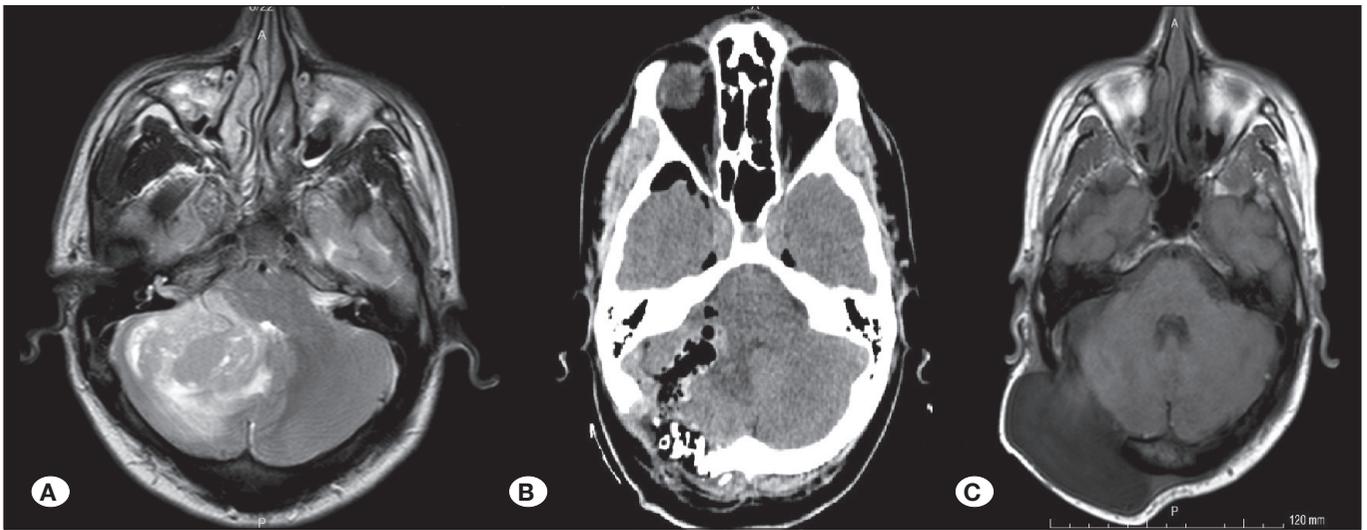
A) The axial section of the cranial T2W magnetic resonance imaging (MRI) sequence shows a cerebellar mass localized laterally but extending to the midline, with brainstem invasion. B) A postoperative axial computed tomography (CT) scan reveals that the mass has been totally excised. C) There is no recurrence or residual disease, but a pseudomeningocele appears at the surgical site in the postoperative first month (cranial axial T1W contrast enhanced MRI scan).
